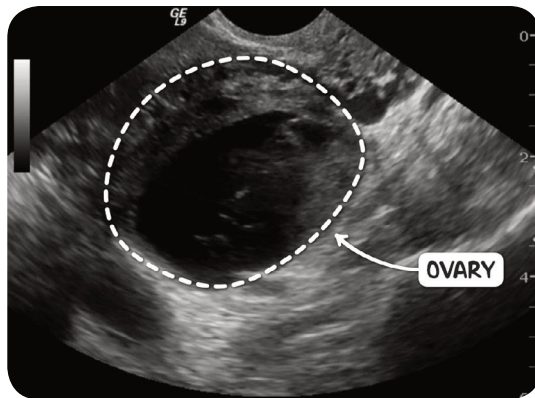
An ultrasound scan of the pelvis in an individual with a hemorrhagic ovarian cyst. The ovary (outlined) contains a large hypoechoic area which has displaced most of the ovarian parenchyma.
